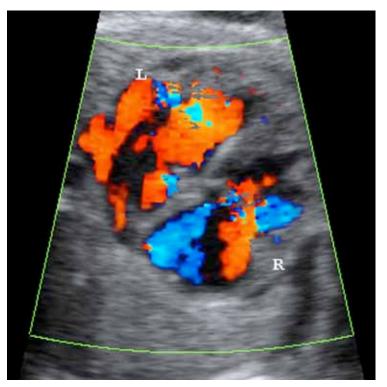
4-Chamber view with color Doppler demonstrating the stiff foramen ovale.
